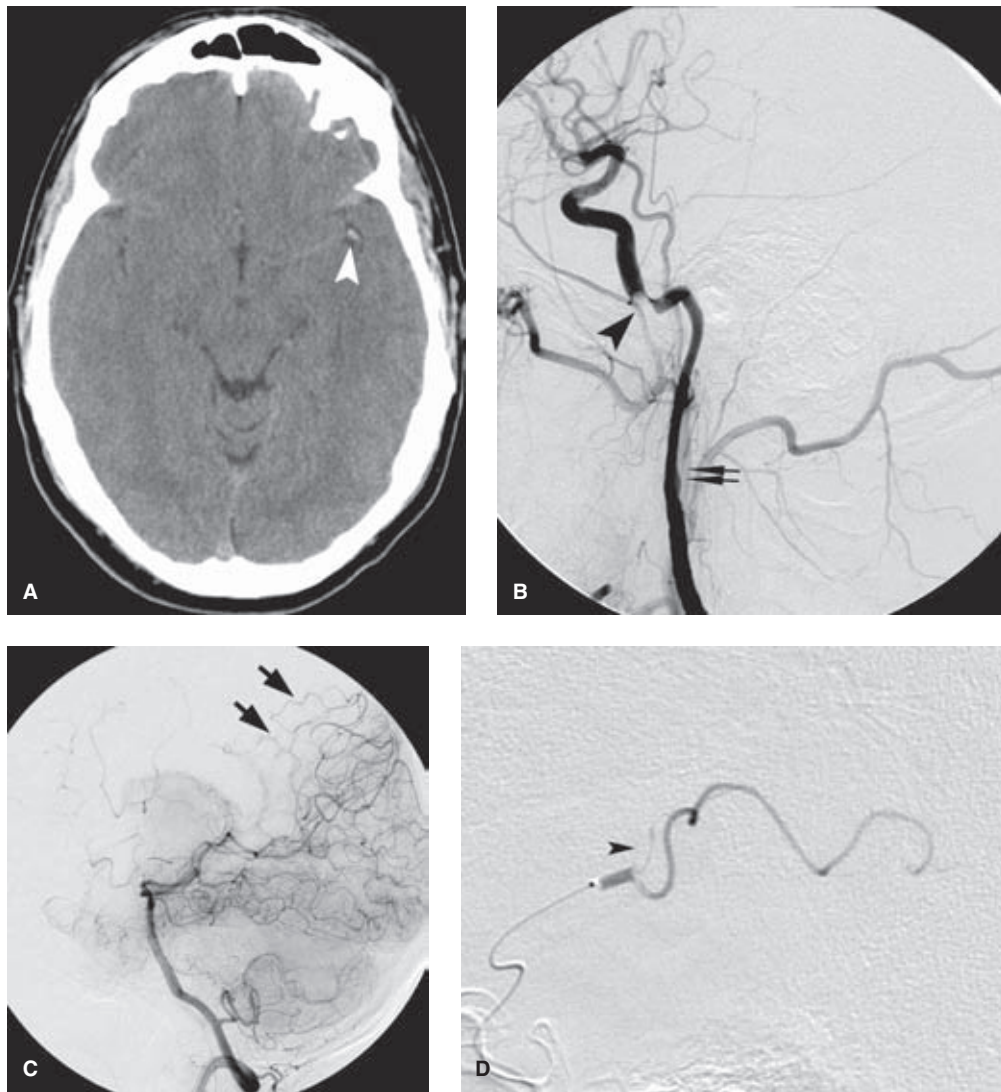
(A–I) Successful thrombolysis in the left middle cerebral artery outside of the 0- to 6-hour window, undoubtedly due to the large role played by the pial–pial collateral vessels. A young father of three children sustained a trivial sports injury to the neck at approximately 7 PM and soon thereafter developed a fluctuating aphasia and right-sided hemiparesis. Largely due to the insistence of his wife despite temporary spontaneous improvement, his discharge home from an outside hospital was countermanded, and he was transferred to our hospital by which time his condition had deteriorated again. His initial 1 A.M. CT (A) demonstrated no evidence of extensive ischemic injury in the left hemisphere, but the left middle cerebral artery trunk and bifurcation show a “dense MCA sign” (arrowhead). His left common carotid artery injection (B) shows an extensive dissection of the left internal carotid artery (double arrows) with a near-occlusive intimal sock (arrowhead) in the petrous section. The posterior division of the left middle cerebral artery is not filling. The superior division is filling well, implying that the embolus seen on the initial CT that caused his presenting aphasia has broken up and moved distally. A left vertebral artery injection taken later during the procedure (C) shows that the patient has some collateral flow (arrows in C) to the distal branches of the affected territory. In one of those instances of inexplicable good fortune, a microcatheter seemed to find its own way past the dissection to the main residual site of occlusion (D), where a saddle embolus (arrowhead in D) sits astride the bifurcation between the angular branch and the parietal branches. This responded very well to an infusion of 250,000 units of urokinase, following which the territorial perfusion was much improved (E). (continued)
